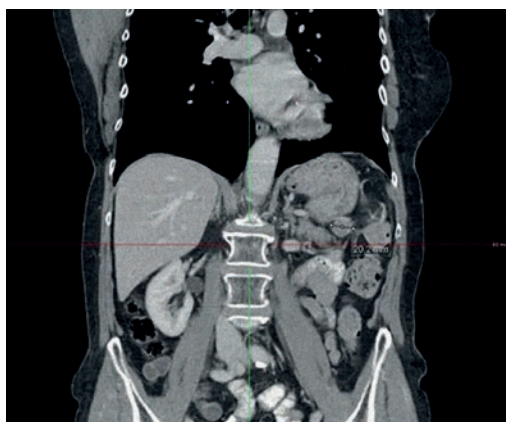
CT scan: peritoneal tumor implants in the gastrosplenic ligament before treatment with trabectedin + PLD.
